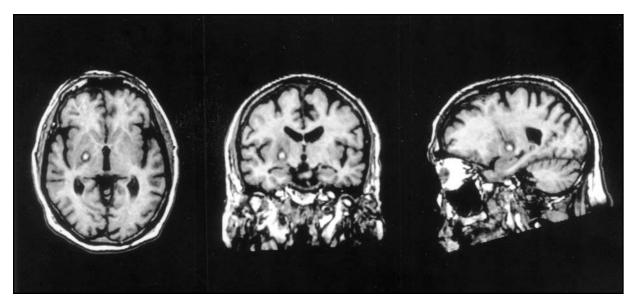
GPi pallidotomy. This T1 weighted MR image taken 24 hours after surgery shows a right pallidal lesion in a patient with Parkinson's disease in axial, coronal and sagittal planes.
